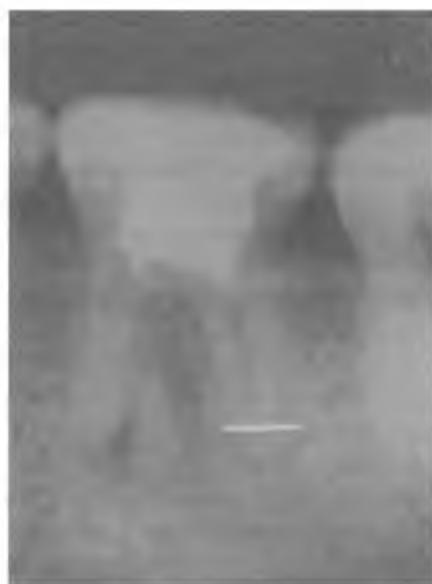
An example of density measurements of root in case of chronic fibrous periapical inflammation
